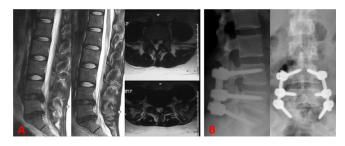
Forty-year-old male patient with back and right leq pain. Sagittal and axial section MRIs (A) are seen. A dream rod was used with dynamic screws. Antero-posterior and lateral radiographic views after the operation (B) MRI: Magnetic resonance imaging
